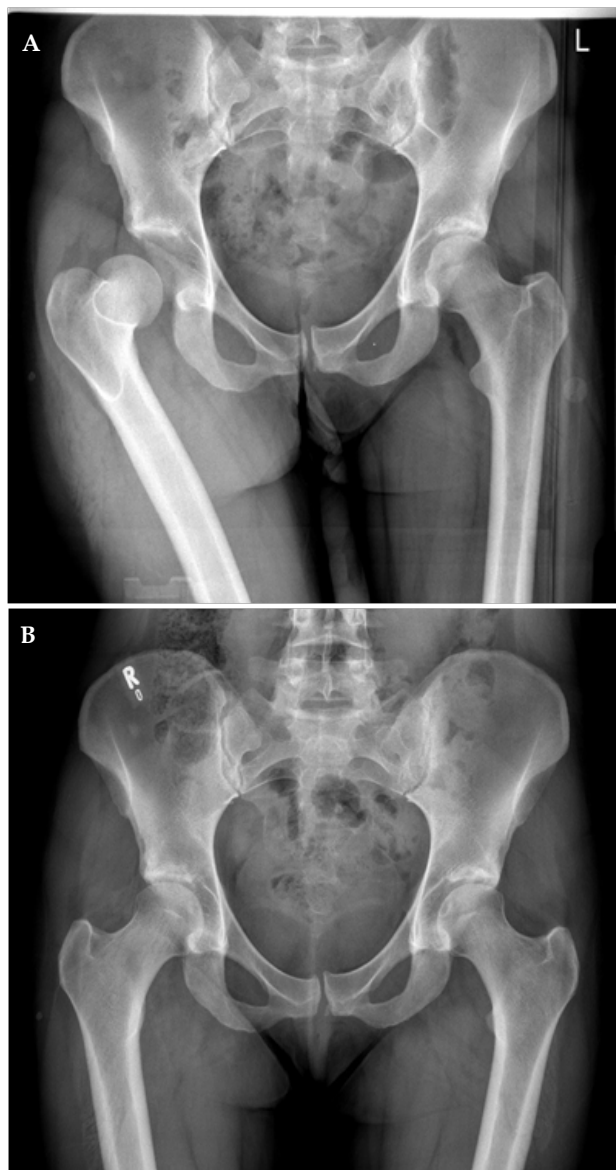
Pre and post reduction pelvic xrays of a 31 year old female who sustained a posterior traumatic hip dislocation without other injury whilst playing Gaelic football. X-ray after closed reduction (B) confirms concentric reduction.
